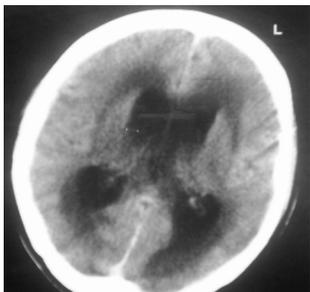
Axial CT scan of brain at the level of lentiform nucleus in an HIV patient (CD4 count <100 cell/ μ L) shows enlarged ventricles and generalized involvement of both lobes by hypodense lesions affecting caudate nucleus, basal ganglia, internal capsule.
